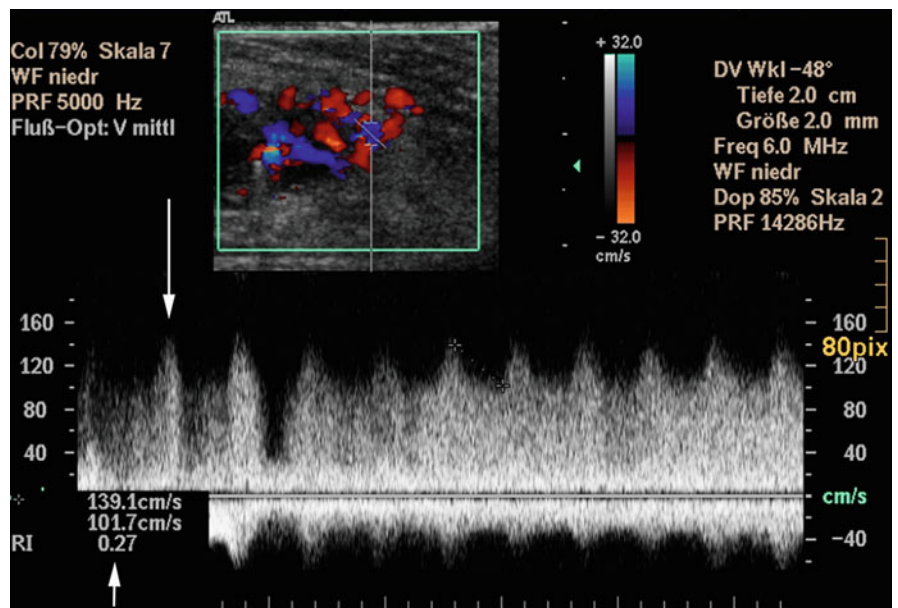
High-flow arteriovenous malformation. Duplex ultrasound: note high-flow velocity of around 139.1 cm/s (long arrow) and high diastolic flow resulting in resistive index (RI) < 0.5 (short arrow) corresponding with marked arterio-venous shunting
